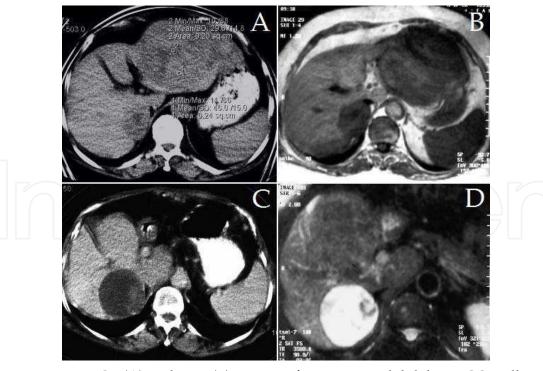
Preoperative CT (A) and MRI (B) images of a patient with bilobar HCC. Follow-up CT (C) and MRI (D) five years after combined operation – RFA of a right-sided lesion which was adjacent to vena cava and resection of the dominant left-sided tumor, demonstrates control of the disease.
